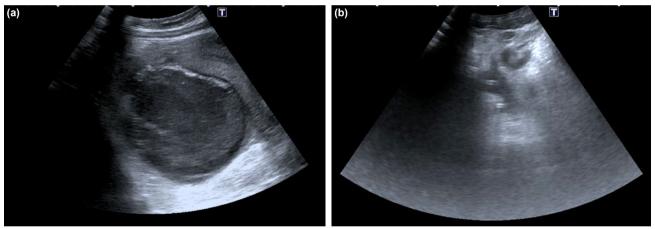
(a) In the ultrasonography examination of the patient who developed pelvic abscess after appendectomy operation, the abscess collection is observed at posterior of the bowel loops and uterus. (b) After transrectal catheter drainage, a reduction in the abscess collection was observed
